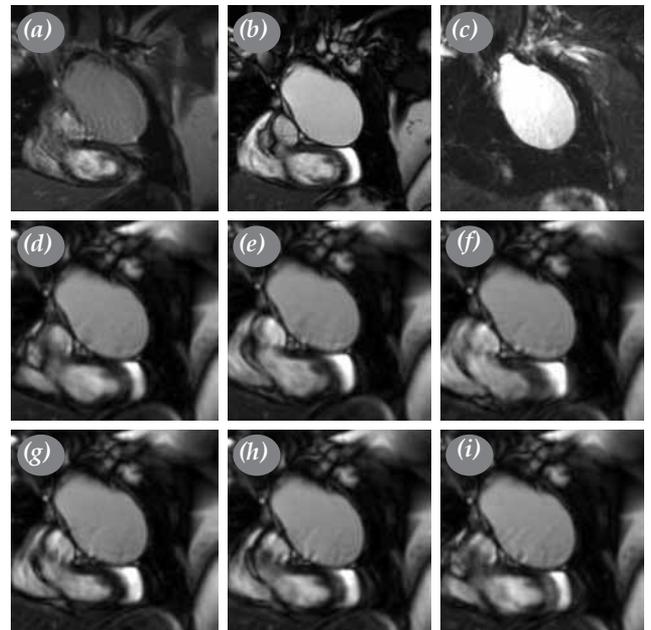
(a) T₁ hypointense; (b) T₂ isointense; (c) short time inversion recovery hyperintense (d-i) mature cystic teratoma which is seen separate from pericard on cine magnetic resonance imaging.
